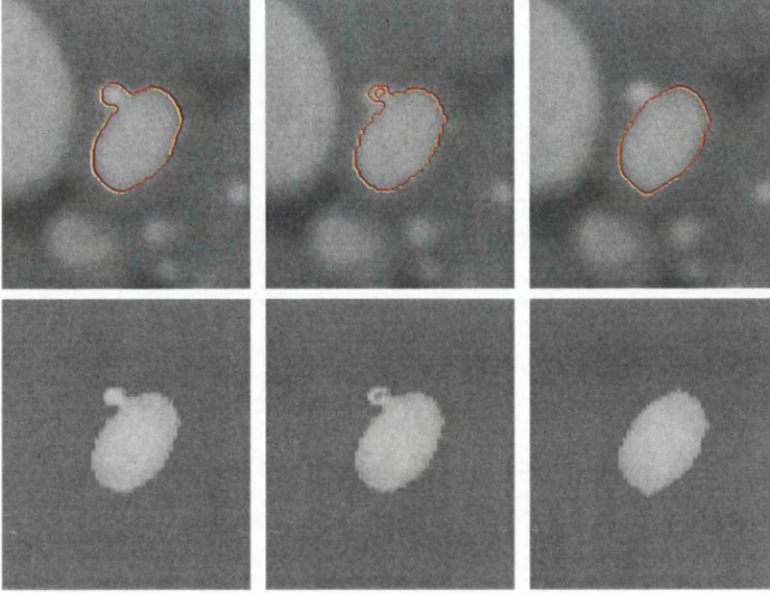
Image slice from CT image dataset 2 showing contours (top row) and corresponding pixels (bottom row) extracted using: from left to right - GPF deformable model, GPF deformable model with intensity threshold and GPF deformable model with region constraint.
